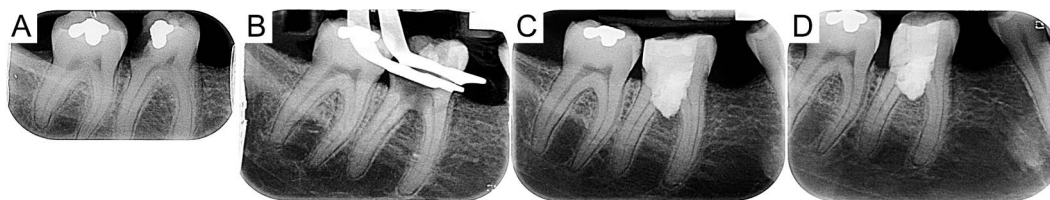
Radiographic documentation provided by the patient at the first visit. (A): Preoperative radiograph and (B) intraoperative periapical radiograph where the iatrogenic furcal perforation of tooth 30 is clearly visible. (C): Immediate postoperative radiograph; after cleaning and disinfection, mineral trioxide aggregate was placed to seal the defect and cover the vital pulp at the canal orifices. (D): One-month control radiograph with no signs of complications.
